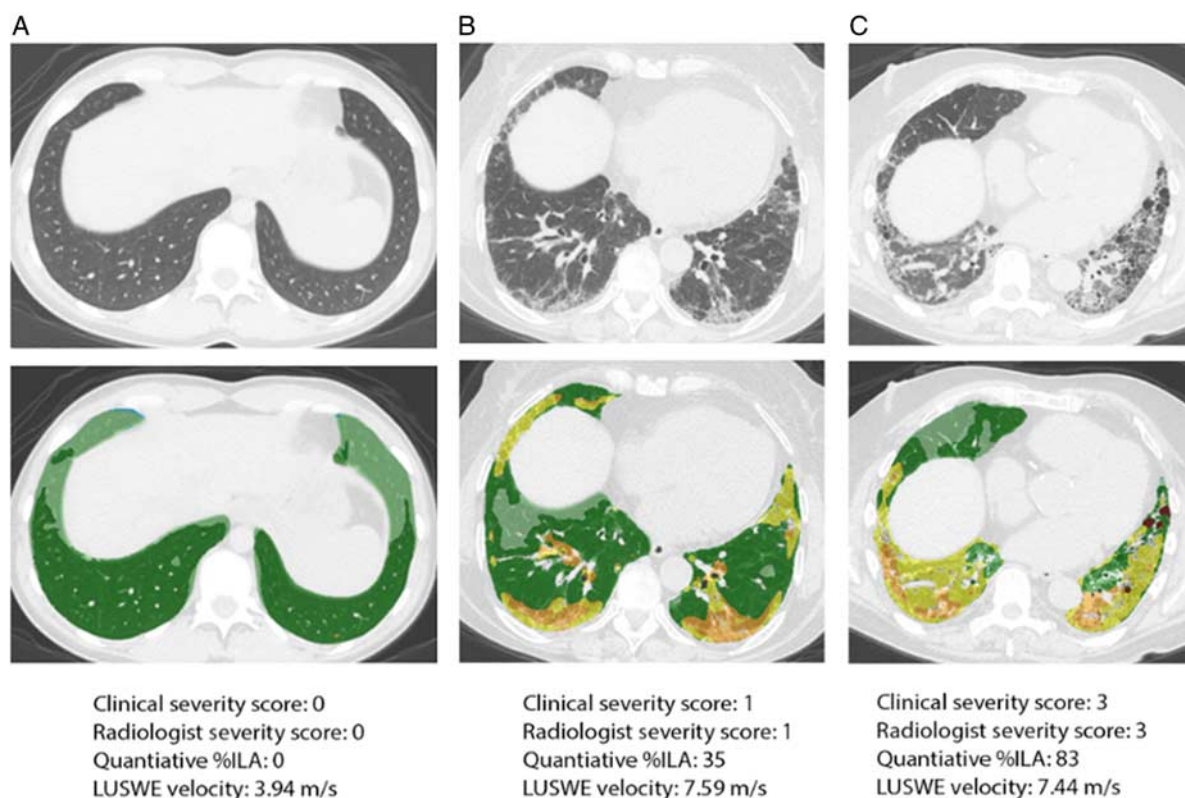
Case examples of LUSWE velocity and radiologic appearance, quantitative analysis, and clinical severity. A, demonstrates a healthy control with a normal CT chest and quantitatively normal lungs color-coded as green and light green by CALIPER. LUSWE velocity is expectedly slow in this healthy subject at 3.94 m/s when compared to cases of ILD. B, depicts a subject with clinically and radiologically mild ILD. Note foci of yellow and orange in the quantitatively analyzed scan depicting zones of ILAs involving 35% of the total lung volume. The LUSWE velocity is significantly higher. C, shows a case with both high clinical and visually assessed severity with diffuse disease involving 83% of the lung as quantitatively assessed, also demonstrating high LUSWE velocity.
